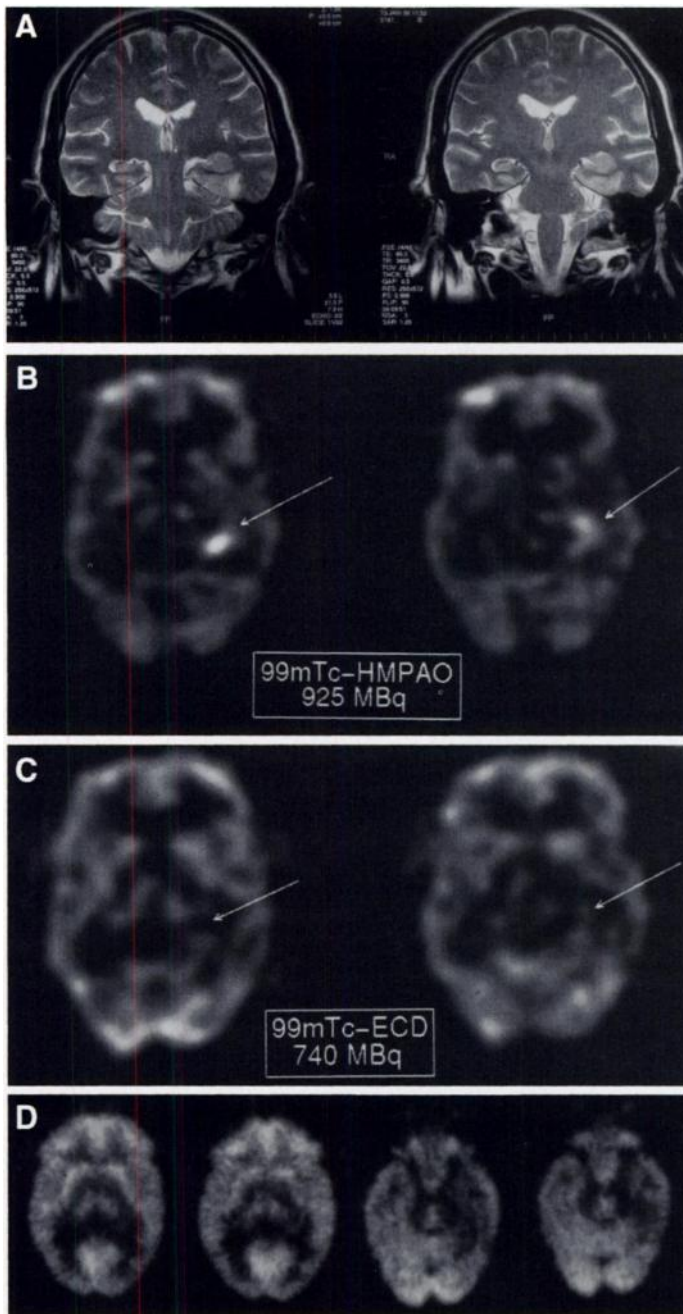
Patient with Grade III astrocytoma (Patient 5). (A) On the coronal view of the MRI (T2-weighted sequence), a left-temporal space-occupying lesion with infiltration of the left hippocampus and characteristics of a low-grade glioma is observed. (B) The interictal ^{99m}Tc -HMPAO SPECT shows, on transaxial views, a left internal and posterior temporal lesion with intense uptake of the tracer. (C) The interictal ^{99m}Tc -ECD SPECT shows heterogeneous cortical perfusion without focal abnormality of the left temporal lobe on identical slices, while ^{201}Tl SPECT shows no significant uptake on this lesion similar to the ^{18}F FDG PET image (D) that shows a left internal and posterior temporal defect without hypermetabolic component.
